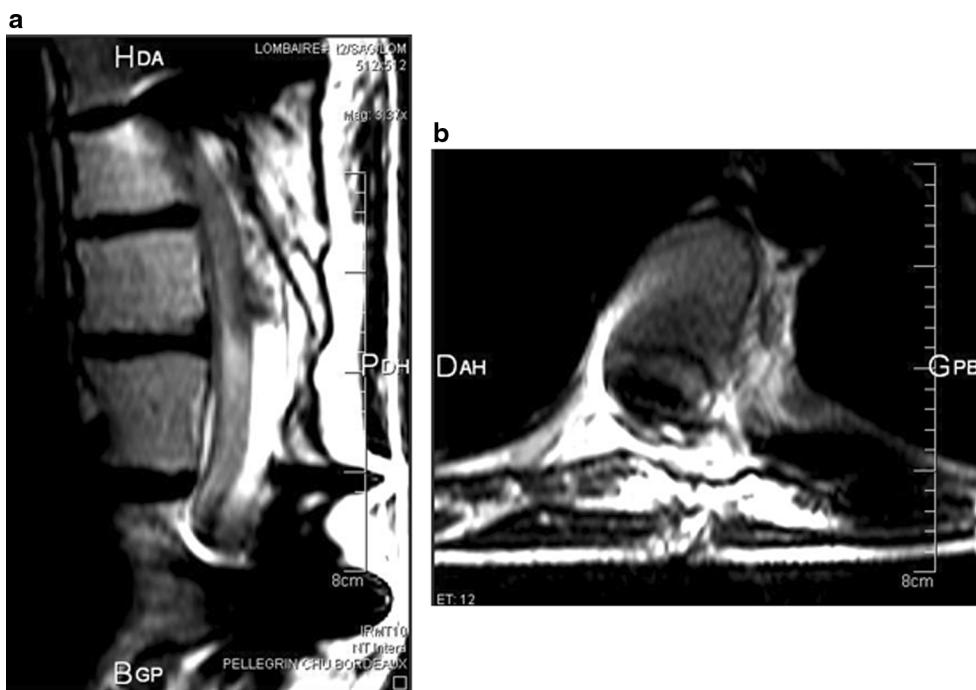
T2-weighted MRI: a sagittal and b axial section showing the rod compressing the spinal cord
